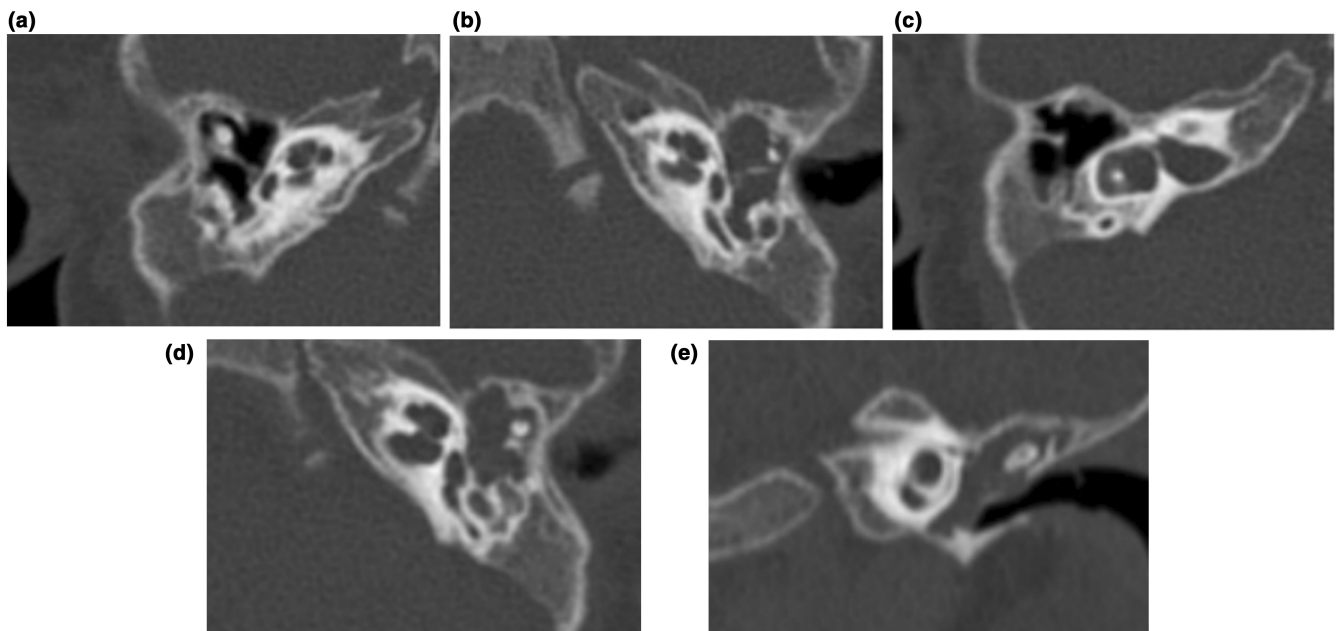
Axial and coronal images of HRCT of patient 1: (a) Right ear: dysplasia of the incus, poor connection of the stapes and the incus. (b) Left ear: the tympanic cavity is filled with effusion; poor connection of the stapes and the incus. (c) Right ear: enlarged vestibule, thick and short horizontal semicircular canal. (d, e) Left ear: the tympanic cavity is filled with effusion; cochlear dysplasia, only the bottom and middle circles were visible.
